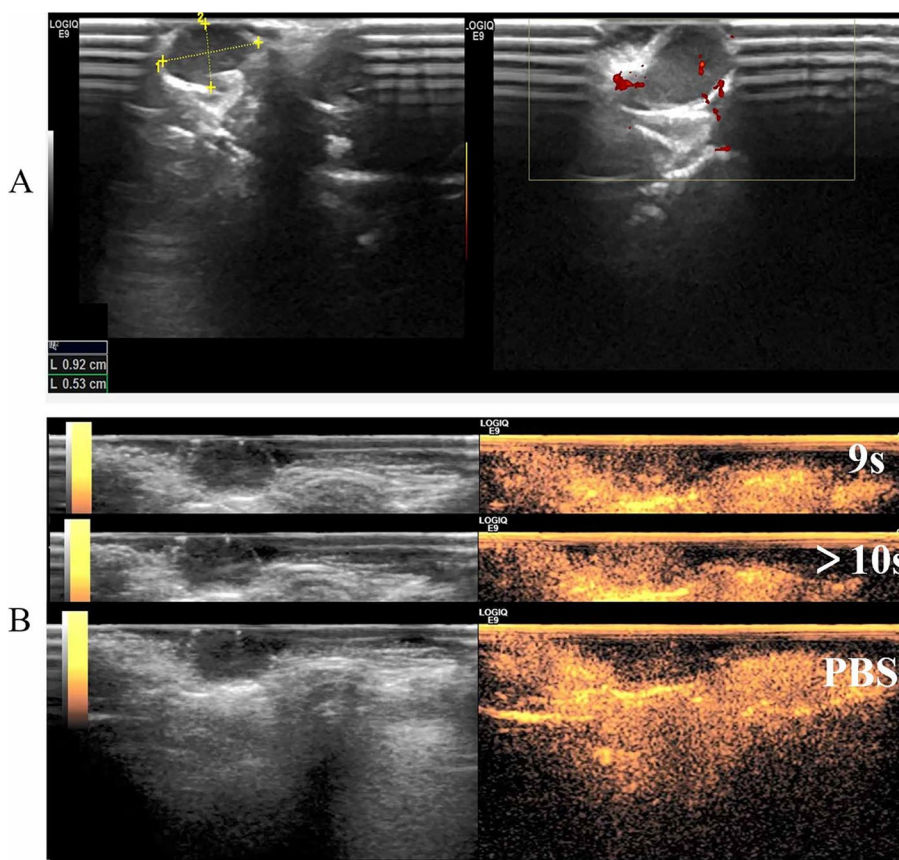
Ultrasound enhancement imaging ability of O-CS-DOX NDs in vivo. a In vivo ultrasound and CDFI imaging ability of O-CS-DOX NDs; b In vivo ultrasound enhancement imaging ability of O-CS-DOX NDs 9 s group, O-CS-DOX NDs 10-60 s group and PBS group
